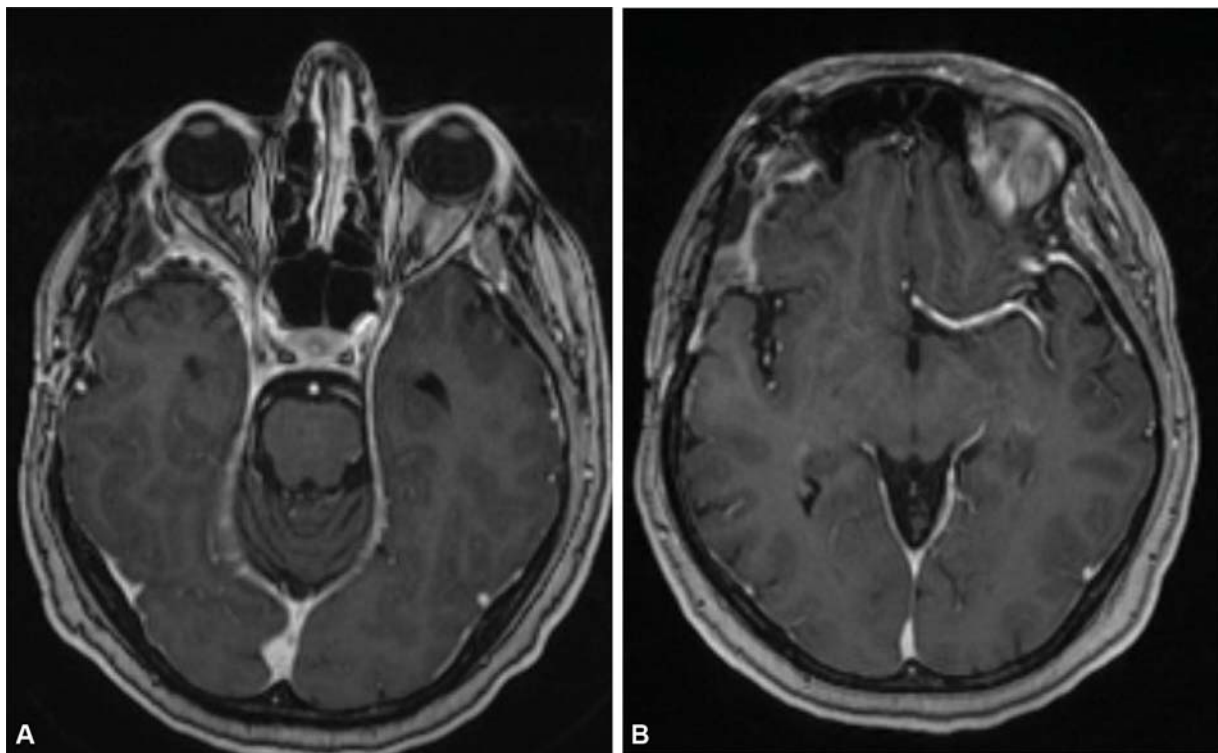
(A, B) Axial MRI post contrast after FTOZ resection of sphenoorbital meningioma shows complete resection of all dural and orbital tumor with complete reduction of the proptosis. Only residual scar can be seen at the site of the duraplasty. FTOZ, frontotemporal orbitozygomatic.
